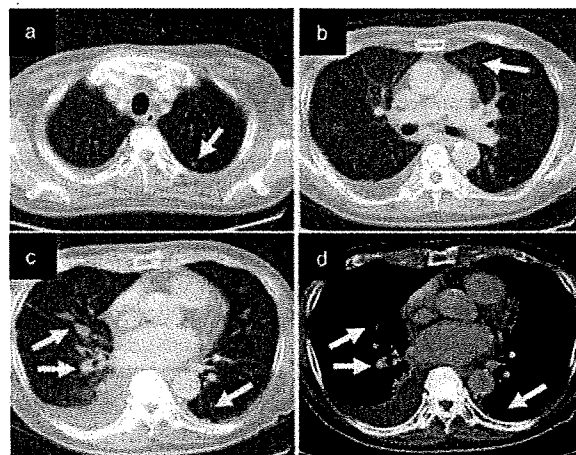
(a-d) Chest computed tomography showed excellent shrinkage of pulmonary metastases after three courses of systemic combination chemotherapy of 5-fluorouracil and interferon- α -2b (arrows). (d) Disappearance of pulmonary metastases infiltrating the right pulmonary artery and appearance of pleuritis at right posterior site with right pleural effusion.
